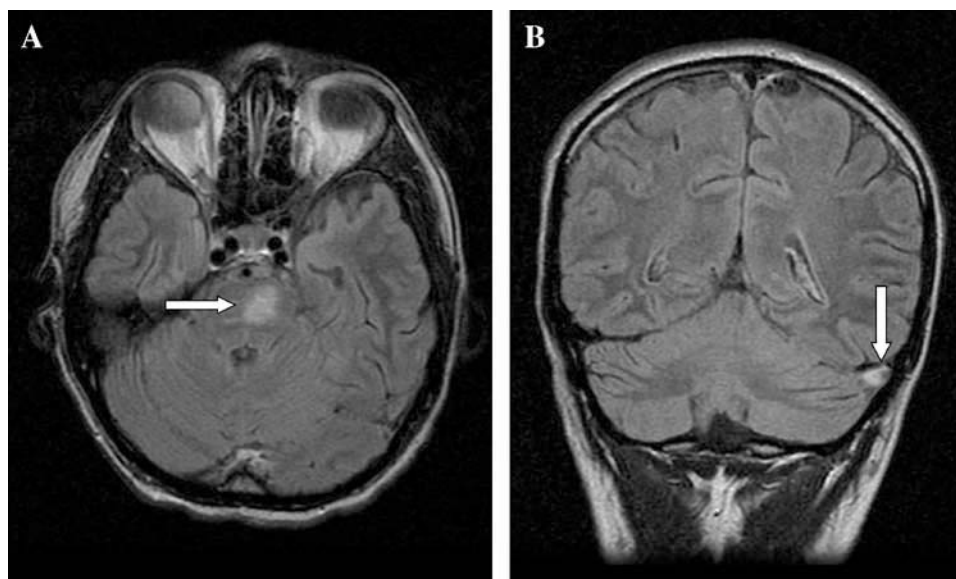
A) Transversal fluid-attenuated inversion recovery (FLAIR) sequence; hyperintense cerebral and stem image (white arrow). B) Coronal FLAIR sequence; left transverse sinus thrombosis (white arrow).
